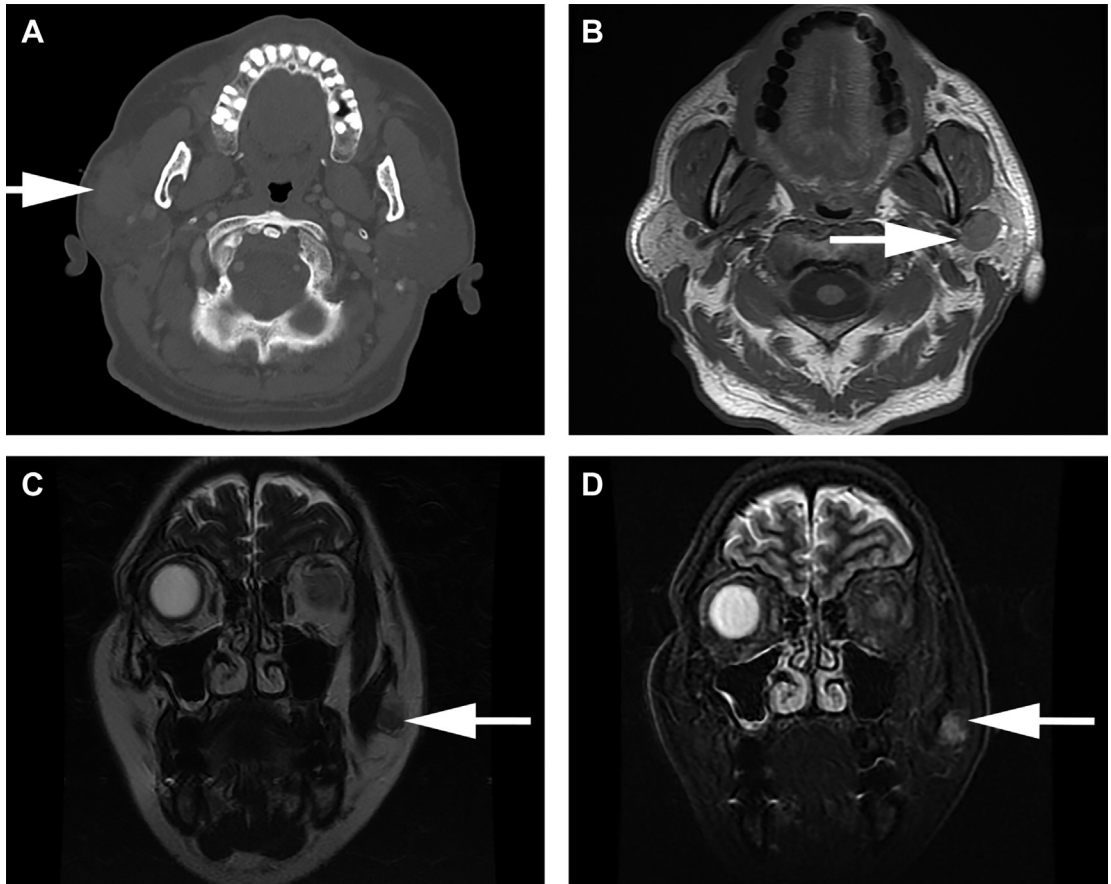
LEC affecting the: (A) Right parotid gland as a soft tissue swelling (*arrow*) by axial computed tomography; (B) A left parotid gland well-defined hypointense mass (*arrow*) on T1-weighted axial magnetic resonance (MR); (C) A hypointense mass (*arrow*) on coronal T2-weighted MR; and (D) Hyperintense mass on coronal T2-STIR (short T1 inversion recovery) sequence MR (*arrow*).
